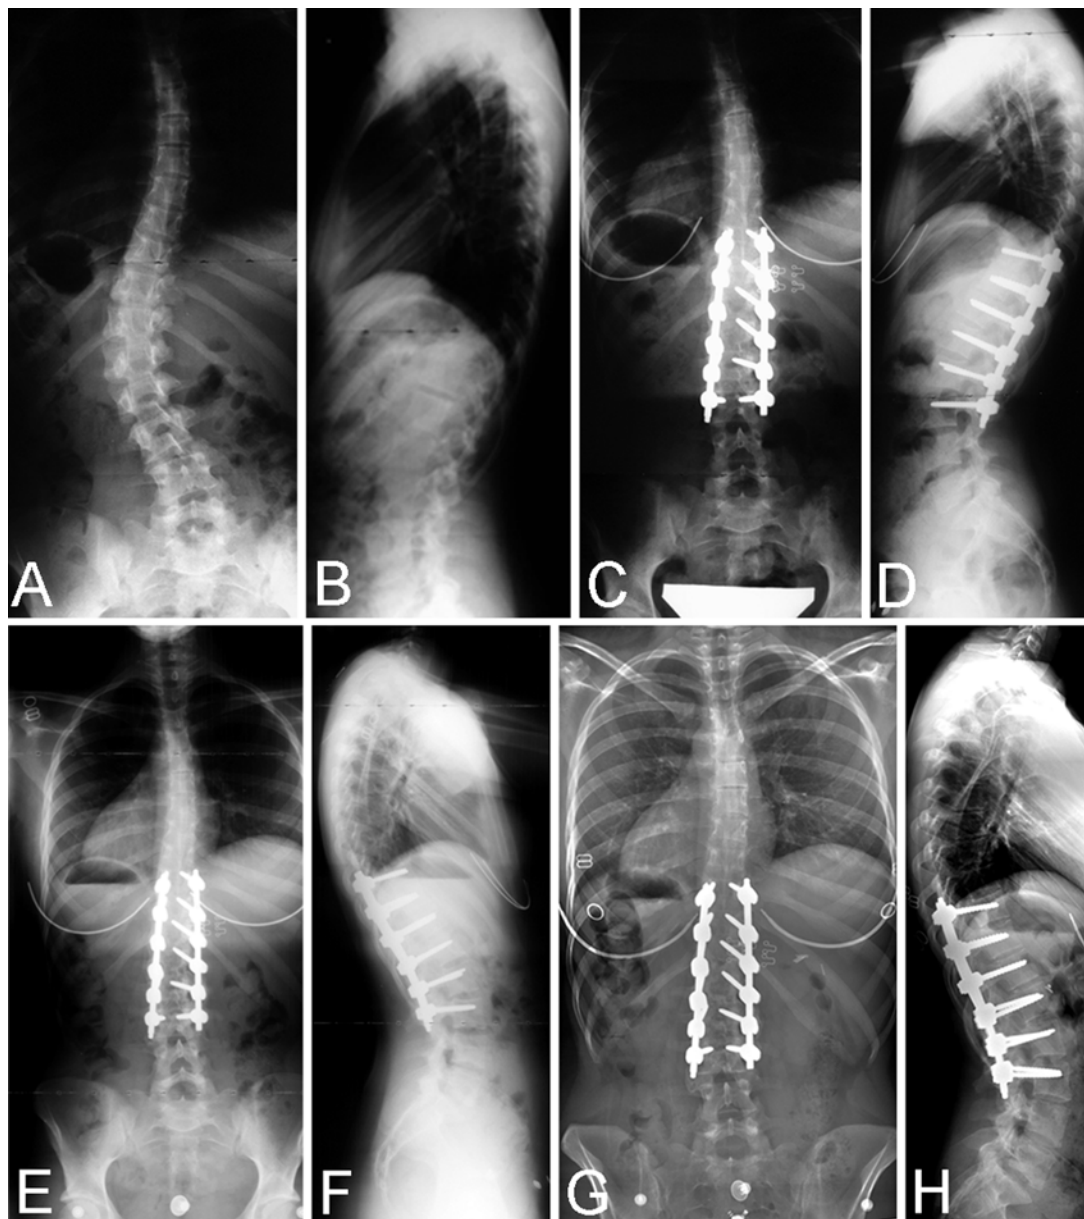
Preoperative standing posteroanterior (A) and lateral (B) radiographs obtained in a 15-year-old girl with a left 48° main thoracolumbar curve and a 29° compensatory thoracic curve. First erect posteroanterior (C) and lateral (D) radiographs obtained after selective posterior spinal fusion with pedicle screws from T-10 to L-3, showing a 2-cm coronal (C7–central sacral vertical line) imbalance to the left. Two-year follow-up posteroanterior (E) and lateral (F) radiographs showing restoration of coronal balance. Five-year follow-up posteroanterior (G) and lateral (H) radiographs showing maintenance of coronal and sagittal correction.
